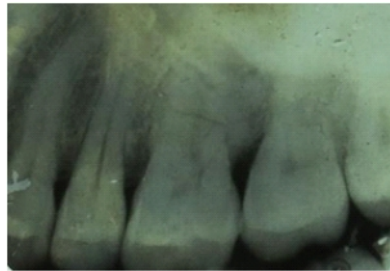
Pre-operative radiograph of the lesion
